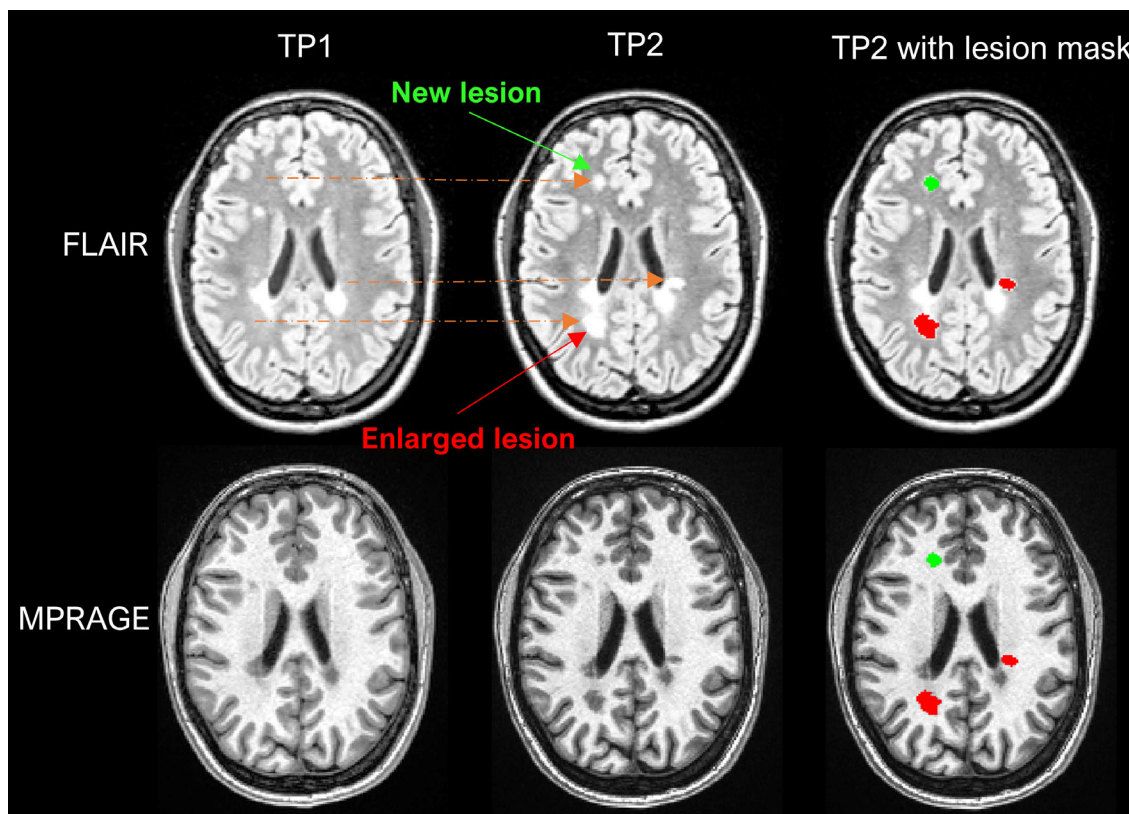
Example of LeMan-PV detecting new and enlarged lesions. The arrows in orange represented in the FLAIR image indicate the region of change from time point 1 (TP1) to time point 2 (TP2) for a new (green arrow) or enlarged (red arrow) lesion. The last column, named “TP2 with lesion mask” represents the LeMan-PV progression map overlapping the FLAIR and MPRAGE in TP2.
